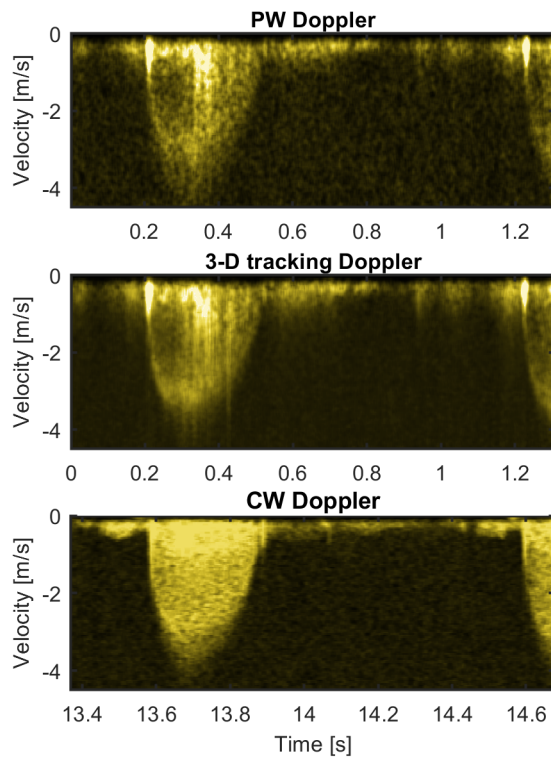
In vivo* example of velocity spectra from subject 4, whose results are summarised in Table III. The estimated beam-to-flow angle was  $38^\circ$ . A CW Doppler spectrum from an apical short-axis view is shown for reference.
